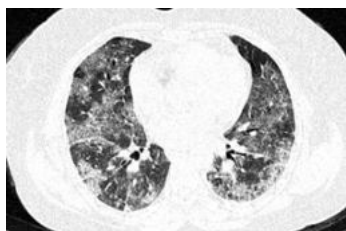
Axial nonenhanced chest CT showing diffuse bilateral distribution of GGOs with crazy paving pattern in both lower lobes in a 55-year-old female.
